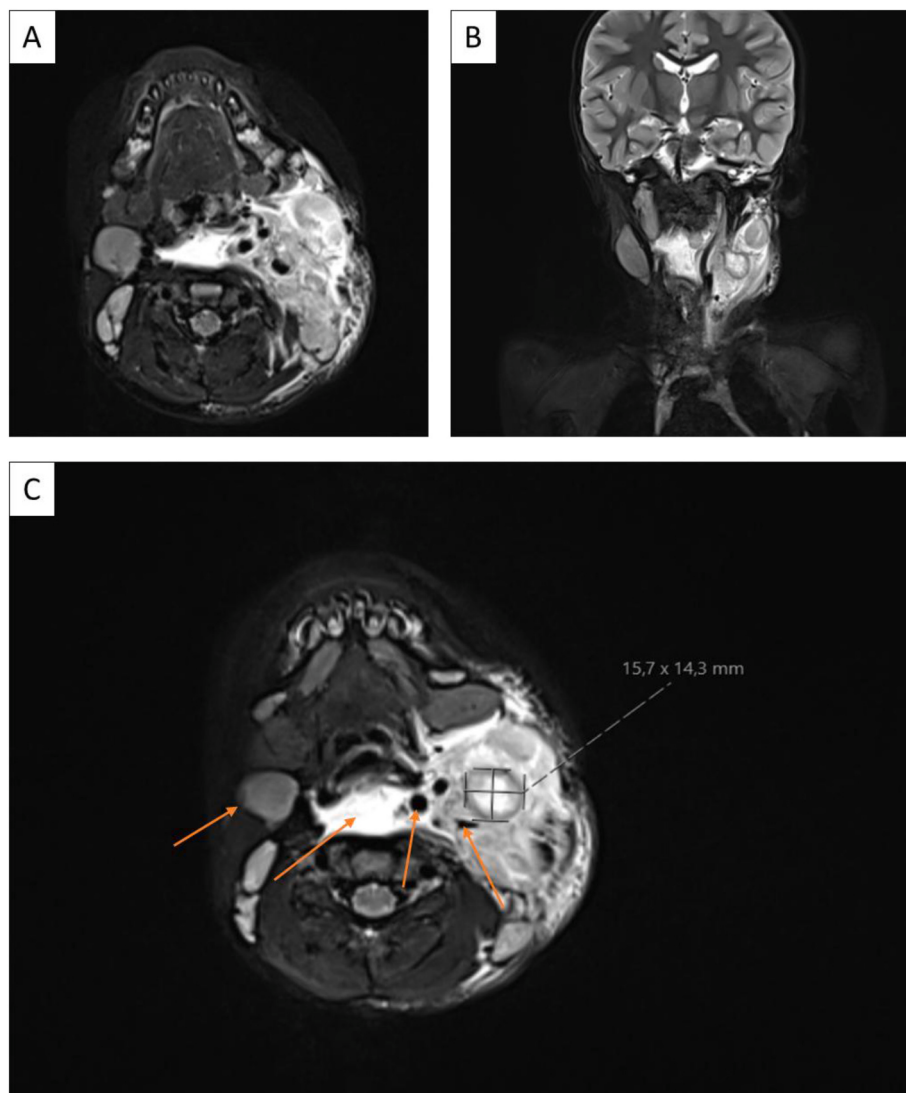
MRI findings of the cervical and prevertebral abscess. A Axial T1-weighted contrast-enhanced sequence shows a deep left-sided cervical process involving multiple levels, with infiltration of the carotid sheath and displacement of adjacent vascular and neural structures. B Coronal T1-weighted contrast-enhanced sequence image demonstrates the cranio-caudal extension of the abscess and reveals pronounced bilateral cervical lymphadenopathy. C Axial contrast-enhanced MRI of the neck demonstrating a well-defined abscess cavity (cross-hairs, measuring 15.7×14.3 mm). From left to right, the arrows indicate: (1) a contralateral cervical lymph node, (2) the prevertebral space containing fluid and showing associated compression of the adjacent pharyngeal space, (3) the internal carotid artery, and (4) the compressed internal jugular vein.
